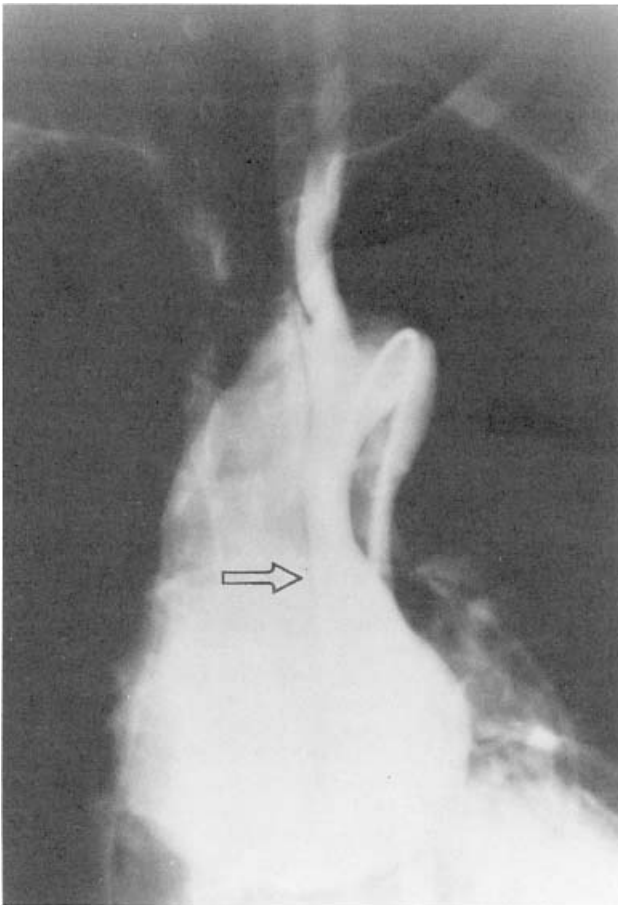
Aortography of a dissected ascending aortic root aneurysm. Anteroposterior radiograph after injection of contrast into the aortic root. The aortic root is markedly dilated, and the arrow points to the intimal flap of the dissection that extends from the valve to the great vessels of the arch. The patient's head is at the top, and the patient's left is to the right of the figure.
